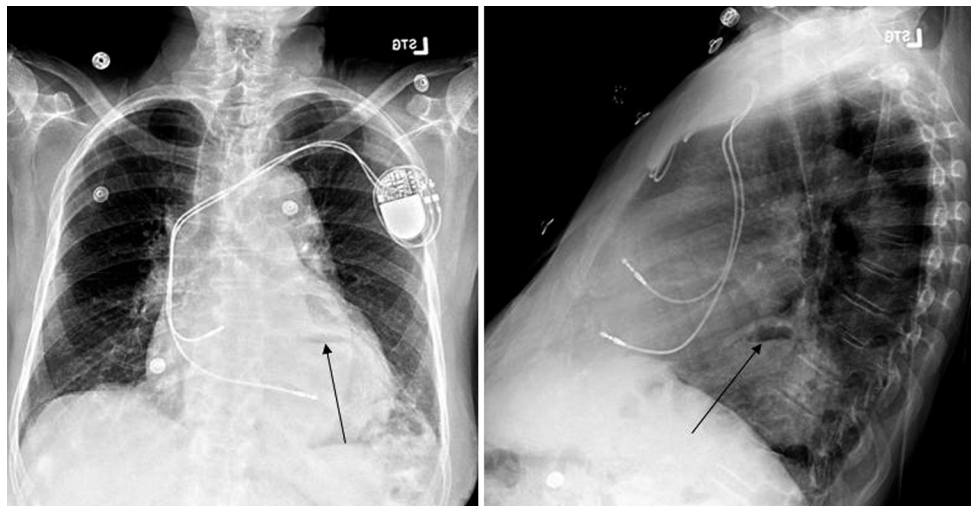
Radiographs of an older man with heart failure, biventricular dilation, a large hiatal hernia (arrows; note the air-fluid level), and pacemaker leads in the right atrium and right ventricle.
